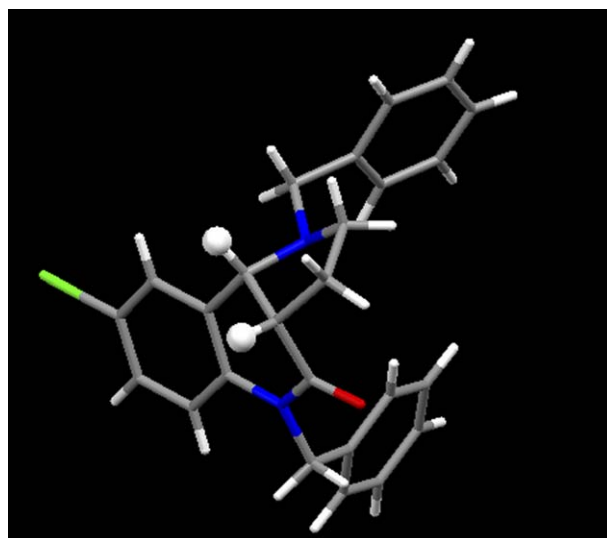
X-ray structure of *cis*-26 (bridge head hydrogens picked out for emphasis).
